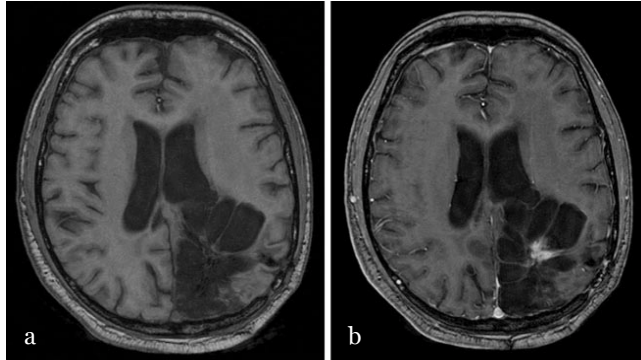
Anaplastic oligodendroglioma*. (a) The unenhanced T1-weighted image does not show any hemorrhage, with a strong enhancement of the solid parts after contrast (b).
